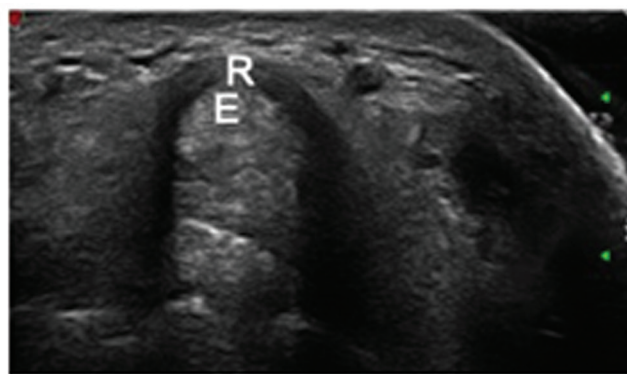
Transverse ultrasound images of the wrist extensor retinaculum and extensor tendons when wrist dorsiflexes from 0° to 60°. When wrist dorsiflexes, an arc shape is formed by the wrist extensor retinaculum and muscle fibers converged towards the top of the arc. R: retinaculum; E: extensor tendons.
